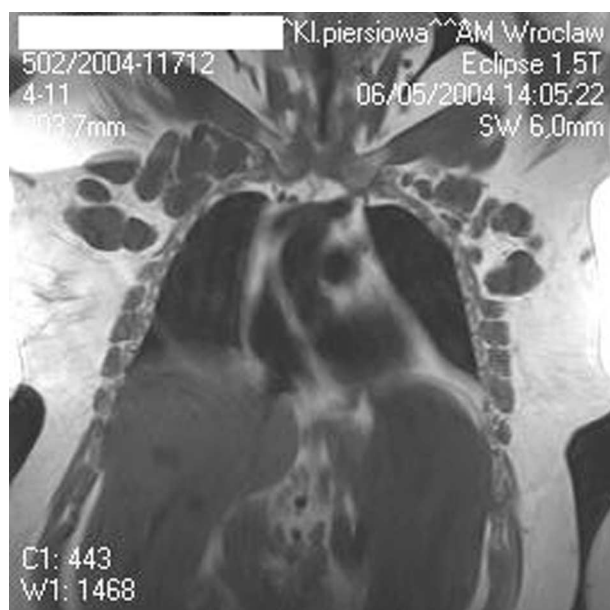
Enlarged lymph nodes in the CT scan of the chest before treatment
